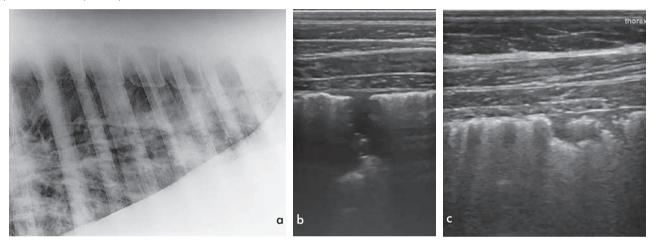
9a: Case 4: Lung radiograph at diagnosis of EMPF. Notice the diffuse nodular interstitial pattern. 9b, c: Case 4: Ultrasonographic finding at diagnosis of EMPF. Notice the roughening of the pleura, the comet tail artefacts (c), and the subpleural consolidation (b). | 9 a: Fall 4: Röntgenaufnahme der Lunge bei der EMPF Diagnosestellung. Zu beobachten ist ein deutlich nodulares interstitielles Muster. 9b, c: Fall 4: Ultraschallbilder bei der EMPF Diagnosestellung. Zu beobachten sind Kometenschweifechos (c), und die Konsolidierung der Lunge (b))
